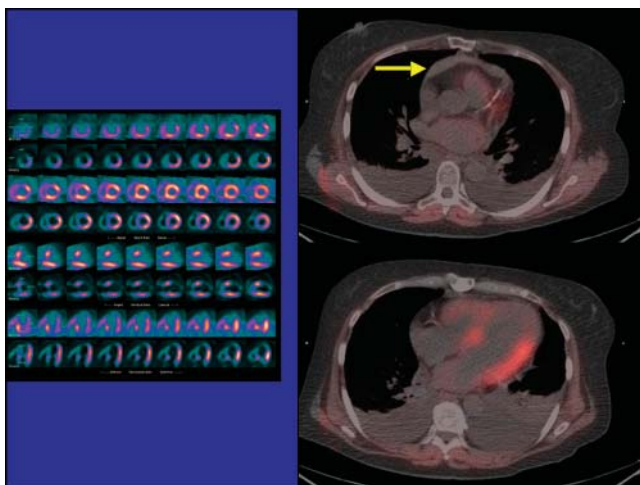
Other incidental findings presented included hemopericardium in a $^{82}\text{Rb}/^{18}\text{F}$ -FDG PET/CT study.
